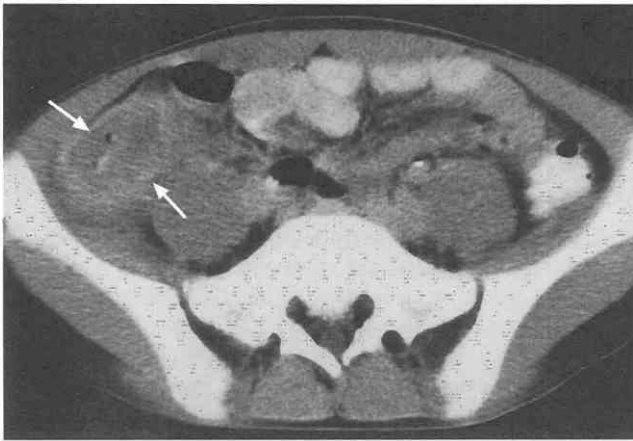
Development of typhlitis during chemotherapy for leukemia. CT scan shows concentric bowel wall thickening (arrows) of the cecum with poor contrast enhancement.
